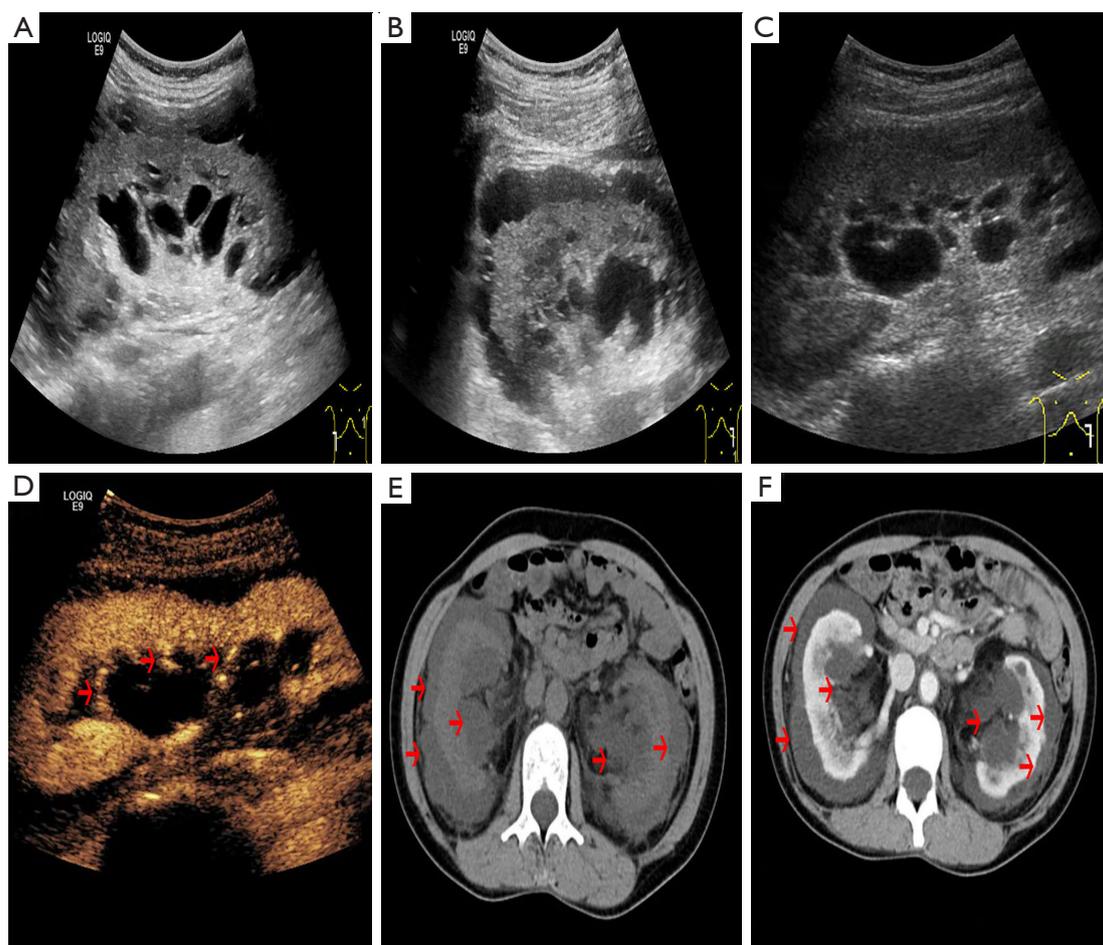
A 30-year-old female with known renal lymphangioma (case 4). (A) Ultrasonographic findings of the right kidney. (B) Ultrasonographic findings of the left kidney. (C,D) CEUS began filling at the 9th second, and reached the peak value at 13th second, and contrast medium filling can be seen in part of the capsule wall and septum (arrows). (E) CT plain scan showed cystic dilatation in the renal pelvis and around both kidneys (arrows). (F) Enhanced CT showed a large amount of fluid around the kidneys and a large amount of fluid within the kidney pelvis (arrows). CEUS, contrast-enhanced ultrasound; CT, computed tomography.
